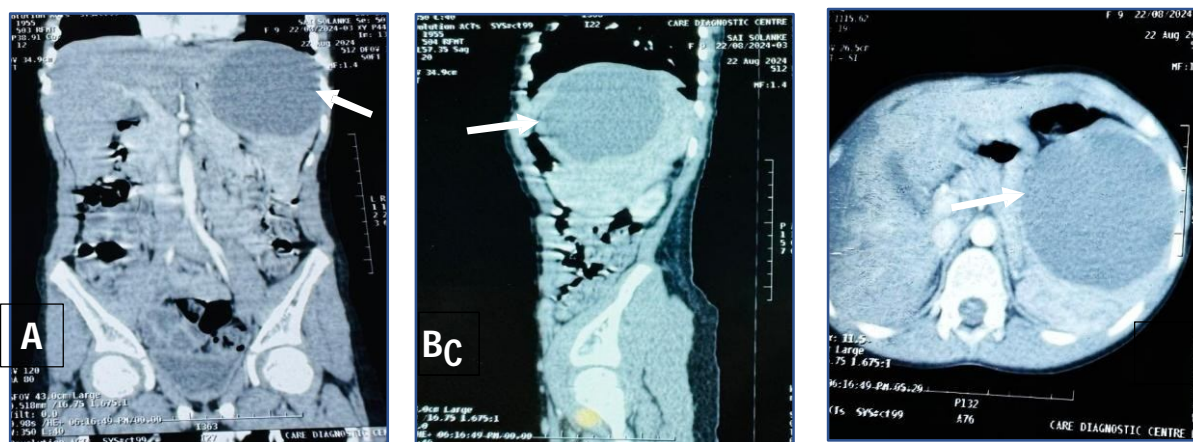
A,B,C-CT Abdomen coronal, Sagittal & Axial view showing a large, Solitary, well defined unilocular cyst in the upper pole of spleen measuring 12x10x9cm
